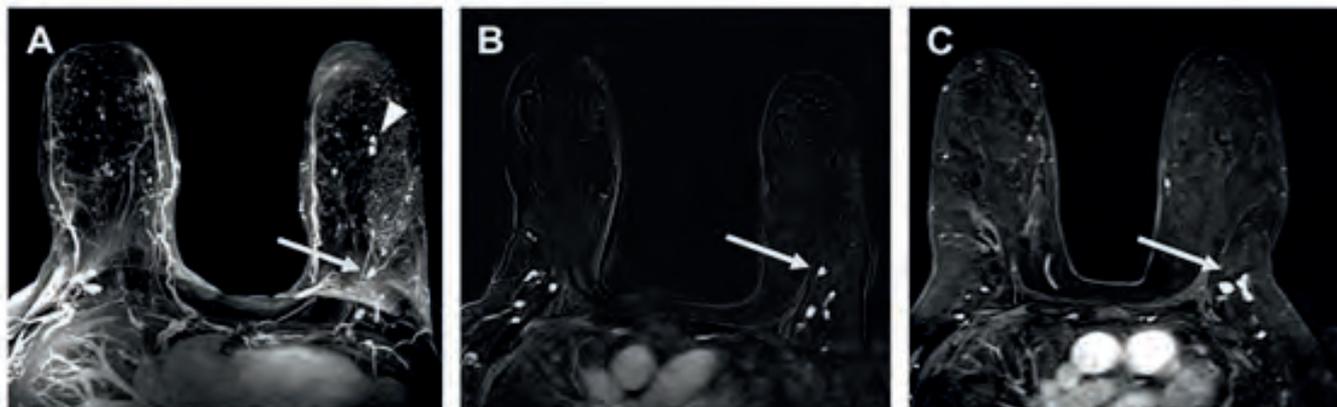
A 56-year-old woman with a personal history of atypia and a strong family history of breast cancer, presenting for high-risk screening. An oval, homogeneously enhancing 0.8-cm mass in the left breast at 2:00 (arrow) seems to be a benign axillary lymph node on MIP image (A), but is slightly anterior to axillary lymph nodes on corresponding first postcontrast subtraction images (B). However, the mass is new compared with prior MR imaging (C). MR imaging-guided biopsy yielded metaplastic carcinoma. Arrowhead denotes a previously biopsied left breast benign masses. Axillary lesions are a known pitfall of MIP interpretation; this area should be reviewed carefully on first postcontrast images. Above figures adapted from Figure 6, ref 37, Heacock et al. *Radiol Clin North Am*.
